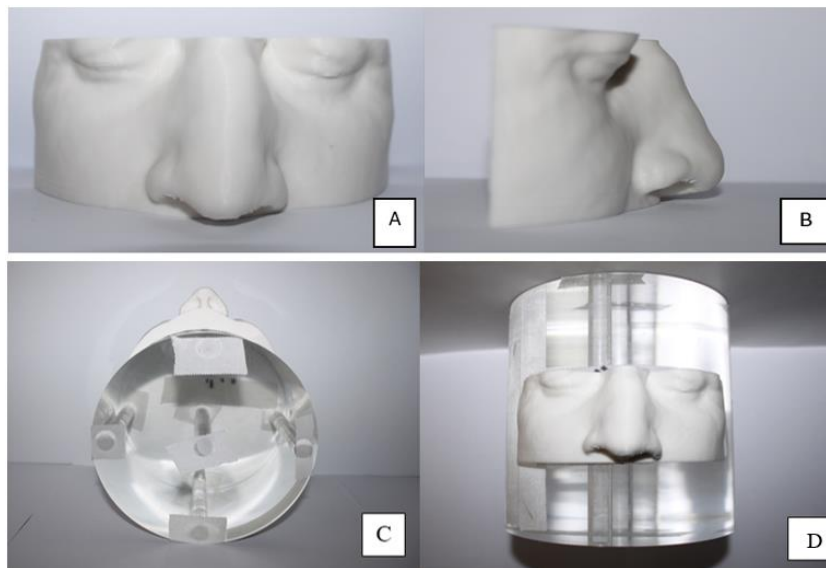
Reconstructed patient’s 3D model from CT scans. A – the longitudinal view of the patient; B – the transverse view of the patient
